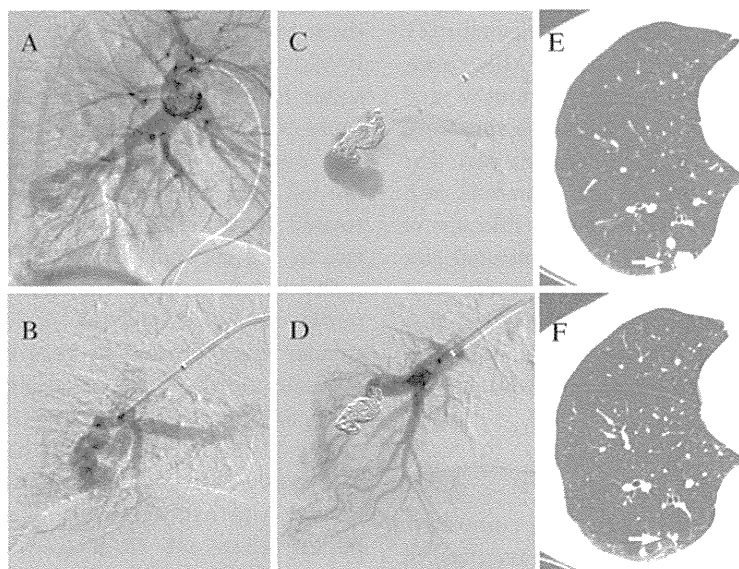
A 66 year-old woman with the right PAVM (Case 2). A. The pulmonary arteriogram (lateral projection) shows a simple type AVM of the posterior segment. B. The selective angiogram shows the tortuosity of the terminal feeding artery beyond the normal branch. C. A microcatheter was advanced as close to as possible to the sac. Following the two oversized 10 mm and 6 mm anchoring bare microcoils, four 6-3 mm hydrogel microcoils were deployed for filling a short segment of feeding artery. Immediately after embolization, a minimal flow remained in the venous sac. D. Post embolization angiogram at 20 minutes shows the complete PAVM occlusion. E. The baseline non-contrast CT image shows the venous sac on the posterior lung surface (arrow). F. The six-month follow-up CT image shows shrinkage of the venous sac (arrow).
